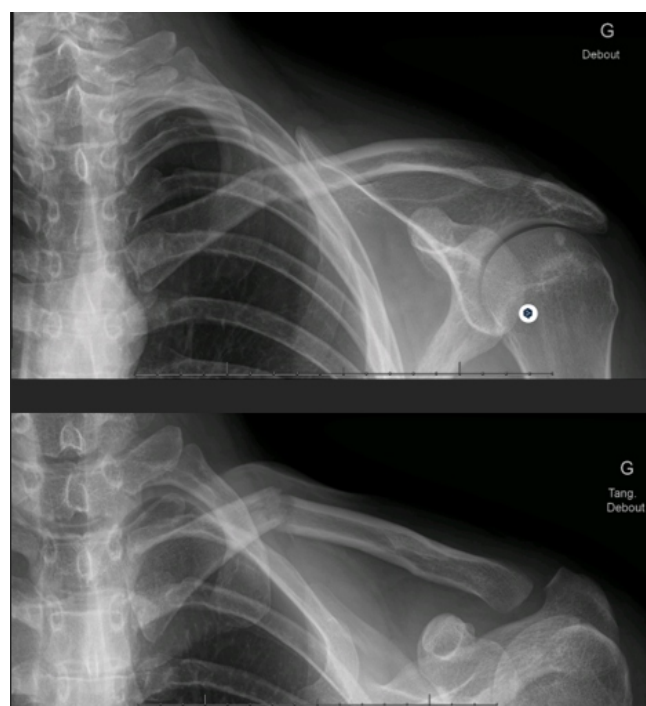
Radiograph taken at the second consultation showing a secondary displacement.
